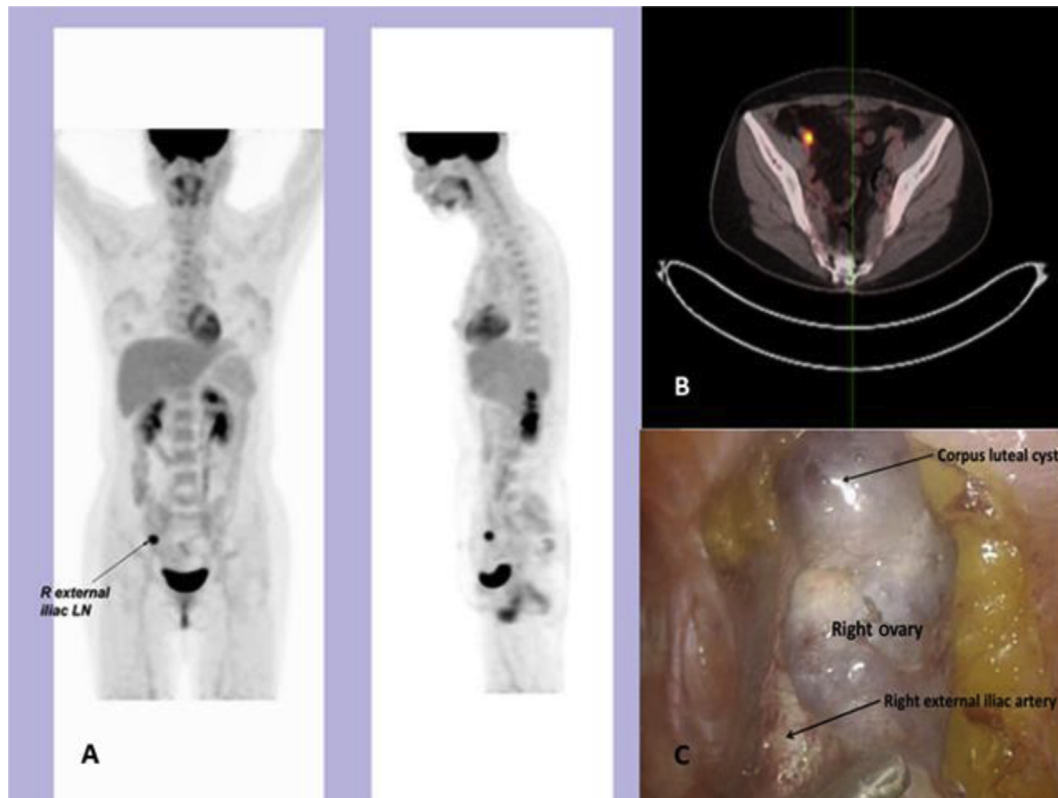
(A) A contrast enhanced computed tomography scan of the chest, abdomen and pelvis showed a round enhancing lesion in the right adnexal region corresponding to the positron emission tomography scan finding of a suspicious lymph node at the right external iliac artery. (B) Transverse pelvic positron emission tomography scan showed a fluorodeoxyglucose avid focus in the right adnexal region. (C) Laparoscopic finding of a corpus luteal cyst at the lower end of the right ovary lying over the right external iliac artery. R, right; LN, lymph node.
